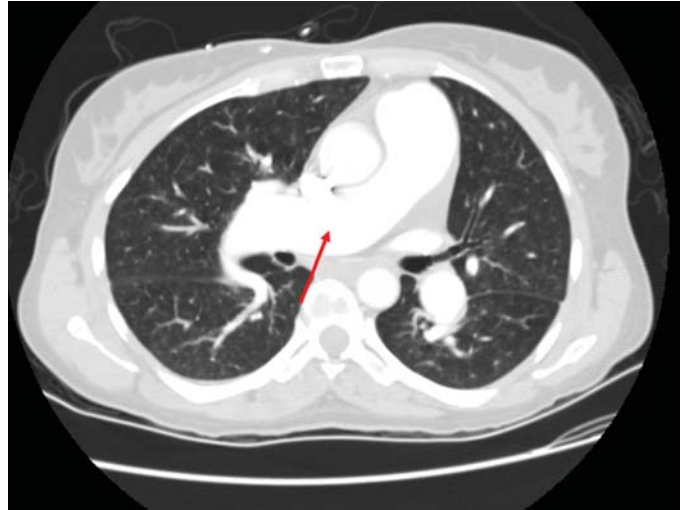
FIGURE e24-50 CT scan of the same patient as in Fig. e24-49. Note the markedly enlarged pulmonary arteries (red arrow).
